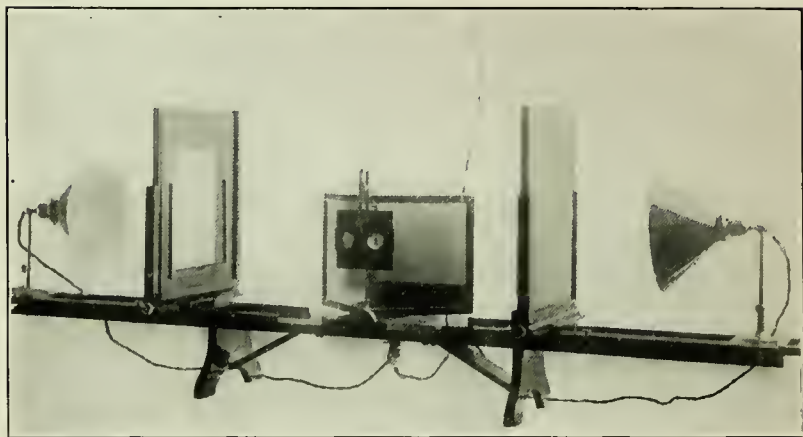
X-Ray Stereoscope.
